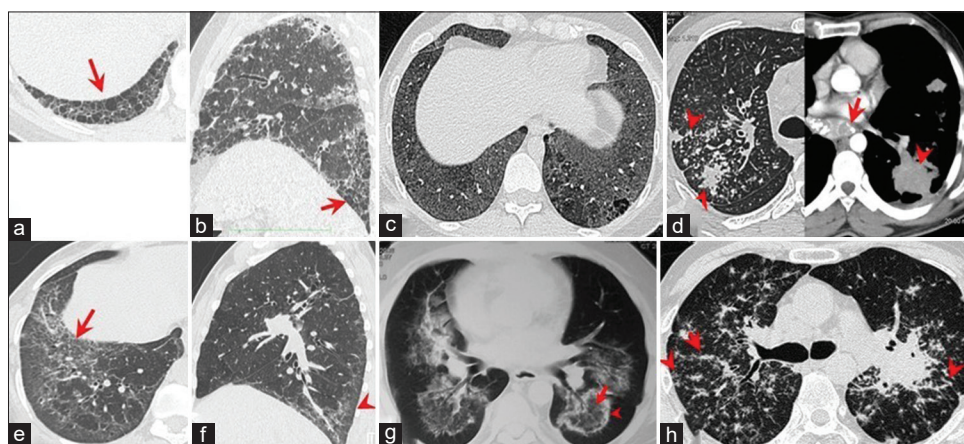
The axial image on high resolution computed tomography (HRCT) of chest (a) shows honeycombing with subpleural lower lobe predominance. The sagittal image (b) shows the subpleural distribution better. This is suggestive of the usual interstitial pneumonia pattern and in the absence of an etiology, would be suggestive of idiopathic pulmonary fibrosis. (c) Hypersensitivity pneumonitis. Axial image shows diffuse ill-defined bronchocentric nodules (arrow) that are characteristic of this condition. These nodules coalesce to form areas of ground-glass attenuation. (d) Silicosis. Axial computed tomography scan shows nodules of varying sizes (arrow) with egg-shell subcarinal node calcification and a confluent soft tissue mass of progressive massive fibrosis. (e and f) Scleroderma interstitial lung disease nonspecific interstitial pneumonia pattern. 34-year-old lady with scleroderma. Axial supine (e) and sagittal (f) images show reticular opacities (arrow in e) with subpleural sparing (arrowhead in f) that are typical of a nonspecific interstitial pneumonia pattern. (g) Cryptogenic organising pneumonia. Axial computed tomography scan shows areas of ground glass attenuation in the centre (arrow) with peripheral consolidation (arrowhead) - this is the typical reverse halo or atoll sign. (h) Sarcoidosis. Axial computed tomography scan shows perivascular (arrow), subpleural (arrowhead) and fissures (short arrow on the left) nodules typical of the disease
